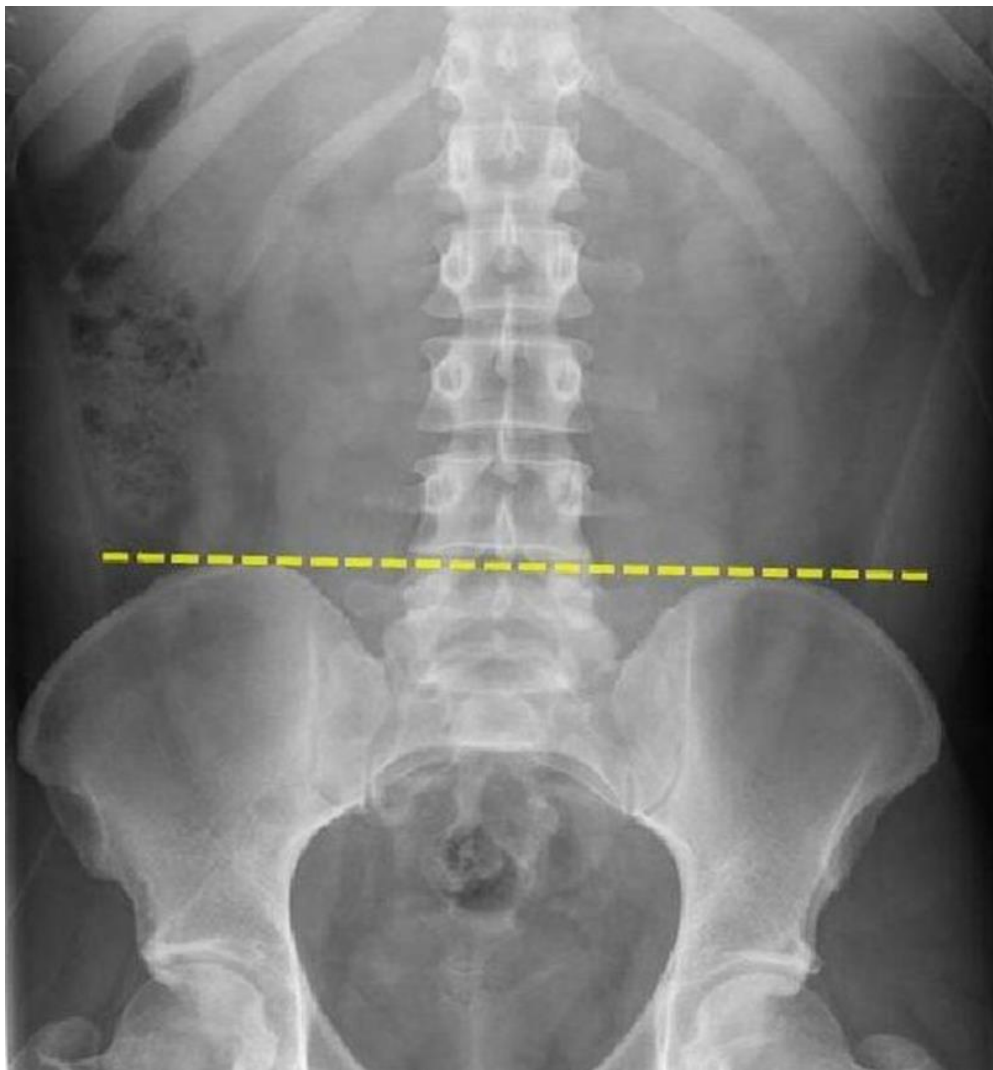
Radiographic measurement of pelvic tilt.
